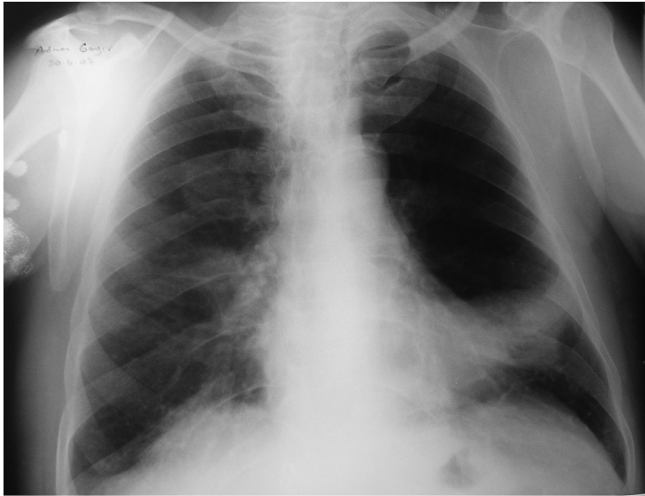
Patient Chest X-Ray on admission.
